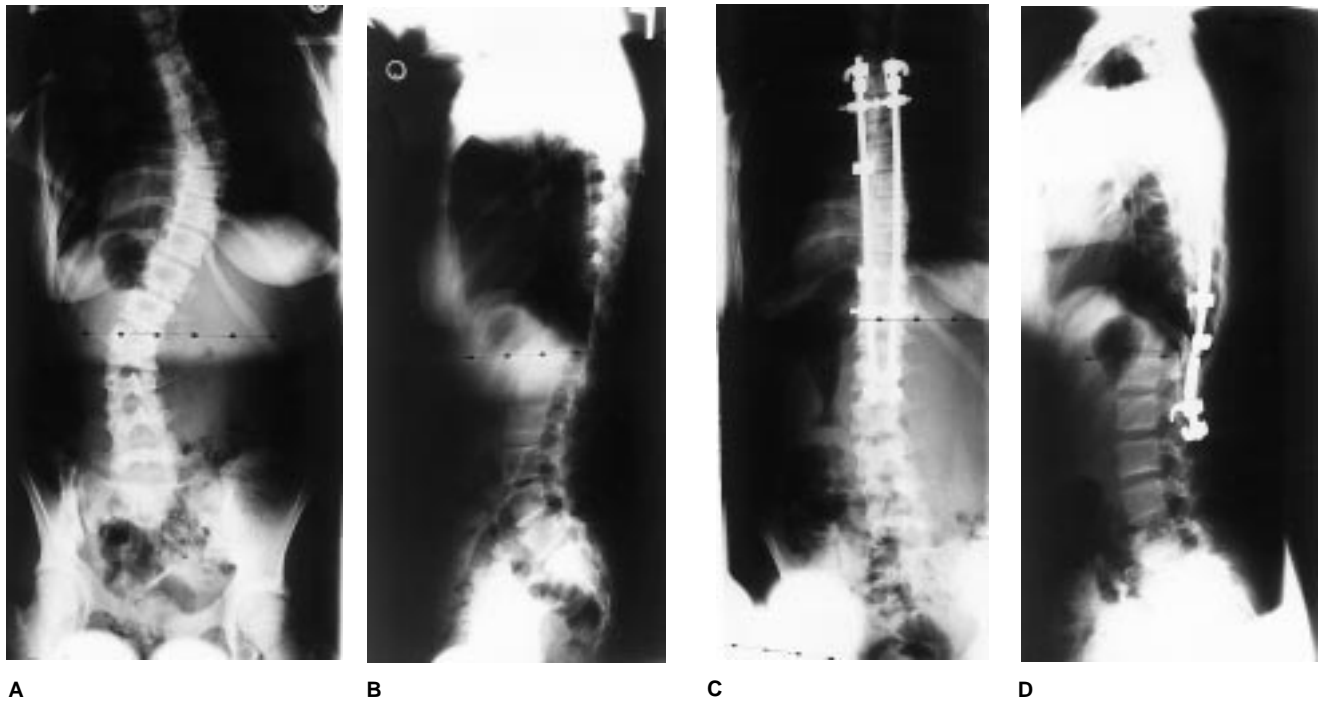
A and B, Preoperative radiographs of a girl aged 9 years 8 months with a 50-degree right thoracic curve. C and D, Postoperative radiographs of same patient demonstrate a thoracic curve of 14 degrees following posterior spinal fusion performed with Isola instrumentation. Sublaminar wires were not used because of the flexible nature of the thoracic curve.
